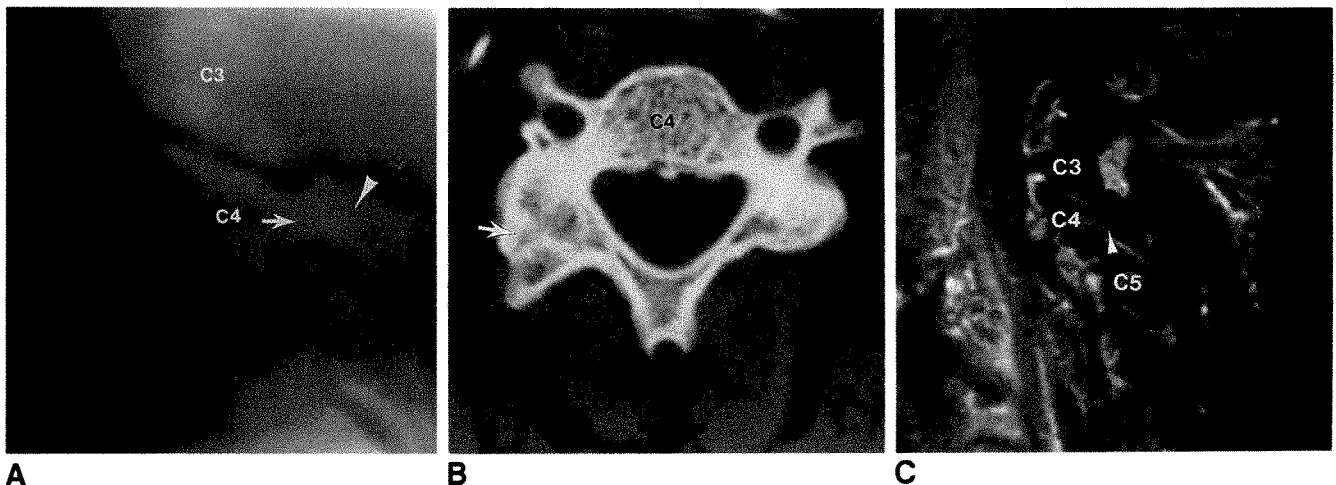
Healed C4 articular mass fracture in a 41-year-old man injured in a motor vehicle accident, thought to have cervical spondylolysis. A, Sagittal tomogram shows posttraumatic deformity of articular mass (*arrow*) and posterior displacement of apparent dorsal fragment (*arrowhead*), which is fused to rest of articular mass, mimicking cervical spondylolysis. No cleft is seen. B, CT scan shows deformed articular pillar without cleft (*arrow*) (compare with Fig. 6.). Pedicle, lamina, and spinous process are normal. C, T2-weighted parasagittal MR image, 2000/40 (TR/TE), shows contiguous marrow signal extending length of healed C4 articular mass fracture (*arrowhead*). Importantly, no cleft is demonstrated, showing this is not cervical spondylolysis.
